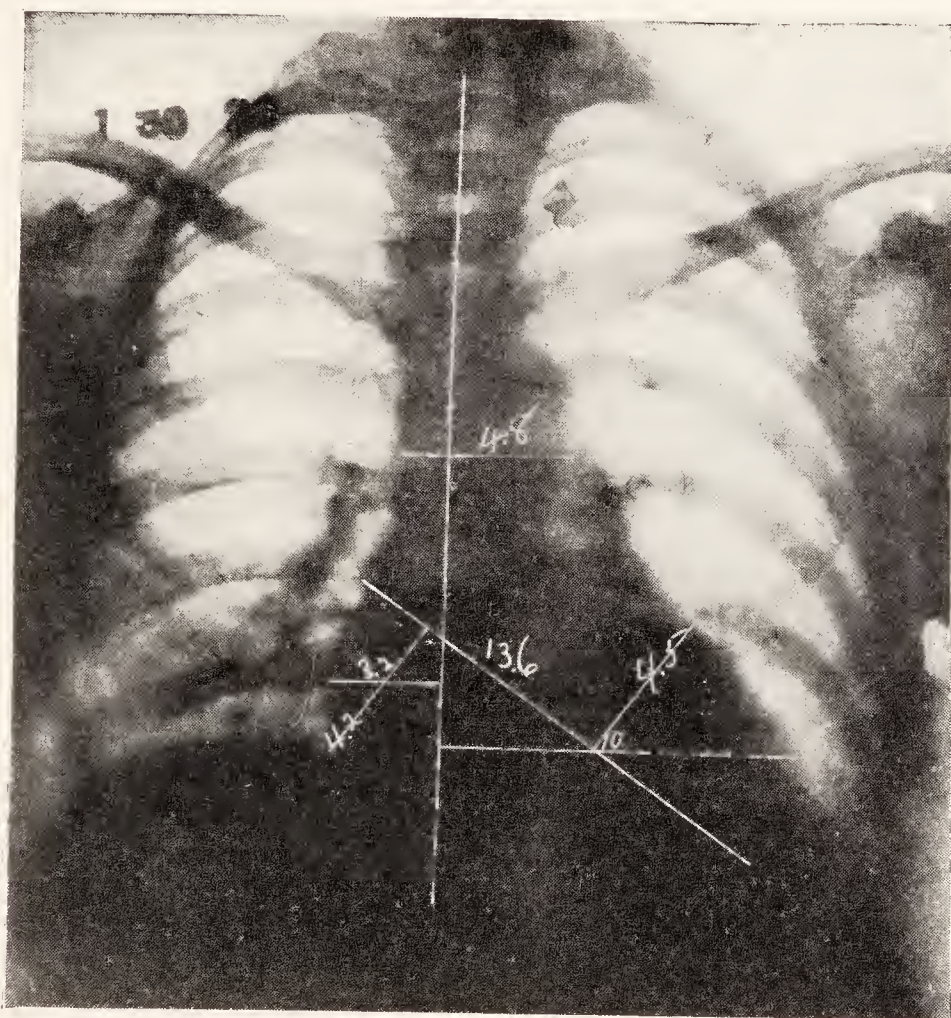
Necropsy 4138. Arteriosclerosis of the aorta with coronary occlusion. Thrombus of the left coronary artery. Mural thrombus of the left ventricle. Hypertrophy and dilatation of the heart. Measurements by X-ray the day before death. (Roentgenological Department, Massachusetts General Hospital.)
